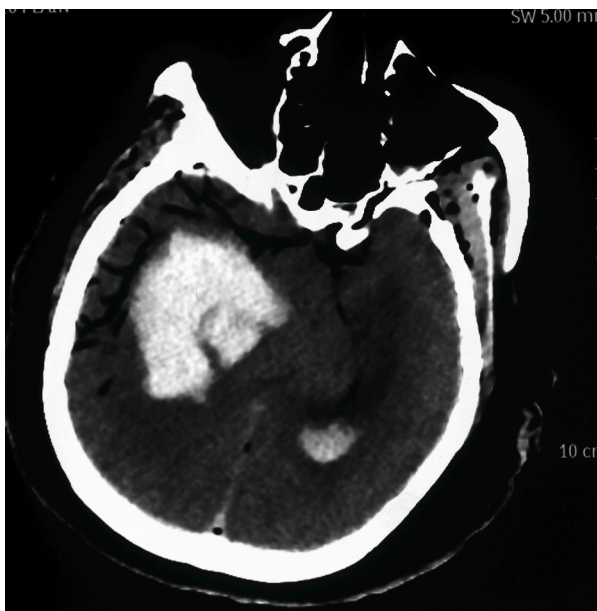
CT Head Axial view: Acute Intracerebral hematoma in the right capsulo ganglionic region surrounded by edema. Also, note the hematoma extending into the left lateral ventricle extension. There is mass effect in the form of right lateral ventricle compression and a midline shift towards the left.
